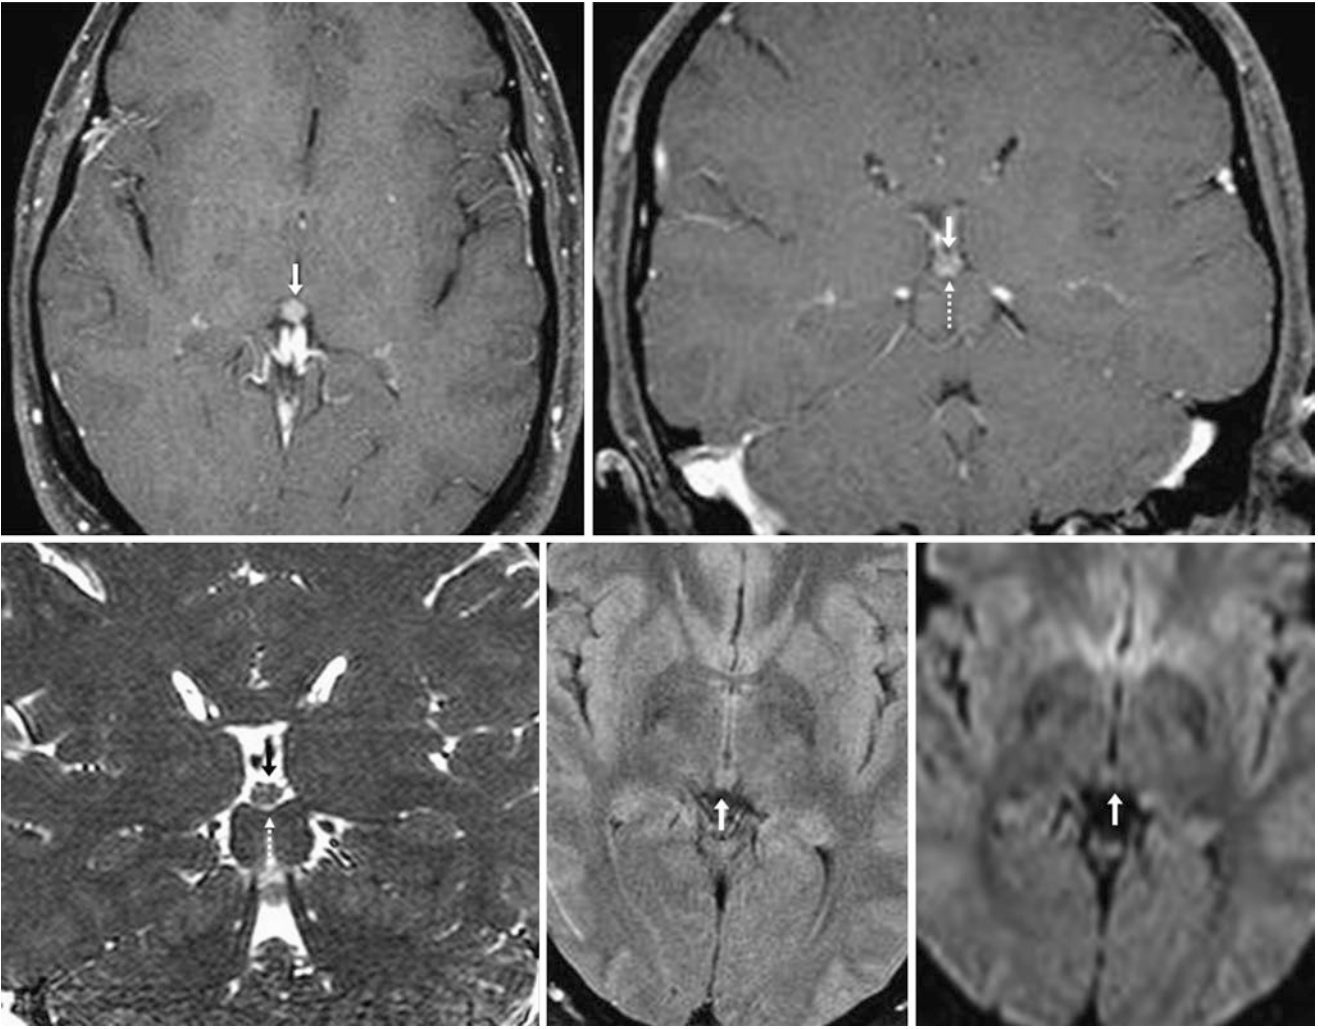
A 27-year-old with a homogeneously enhancing 9-mm pineal gland (*arrows*) on postcontrast axial (*top left*) and coronal (*top right*) T1WI, on coronal balanced CISS/T2WI (*bottom left*), and on axial FLAIR (*bottom middle*). No reduced diffusion is noted (*bottom right*). It is adjacent to but does not compress the tectum (*dotted arrows*)
